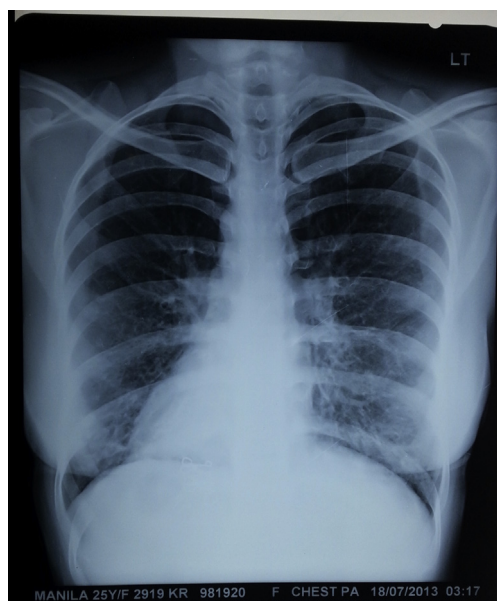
Chest X-ray showing dextrocardia with bronchiectatic changes in lower lung zones, more on the left side.
